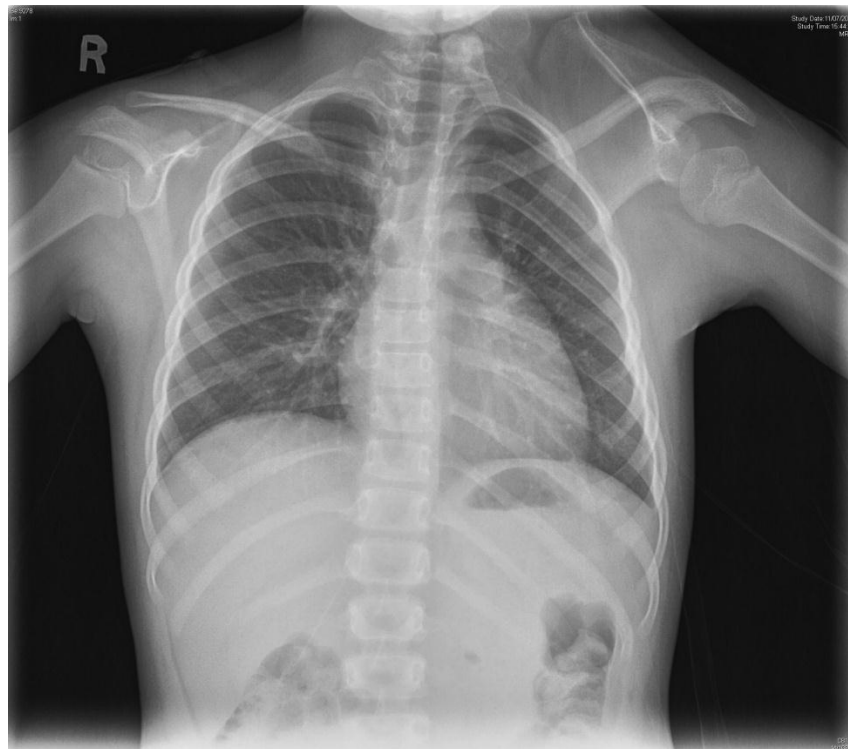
X-ray showing elevated scapula on left side pre-op with Rigault's grade-2 of a 3years old child
